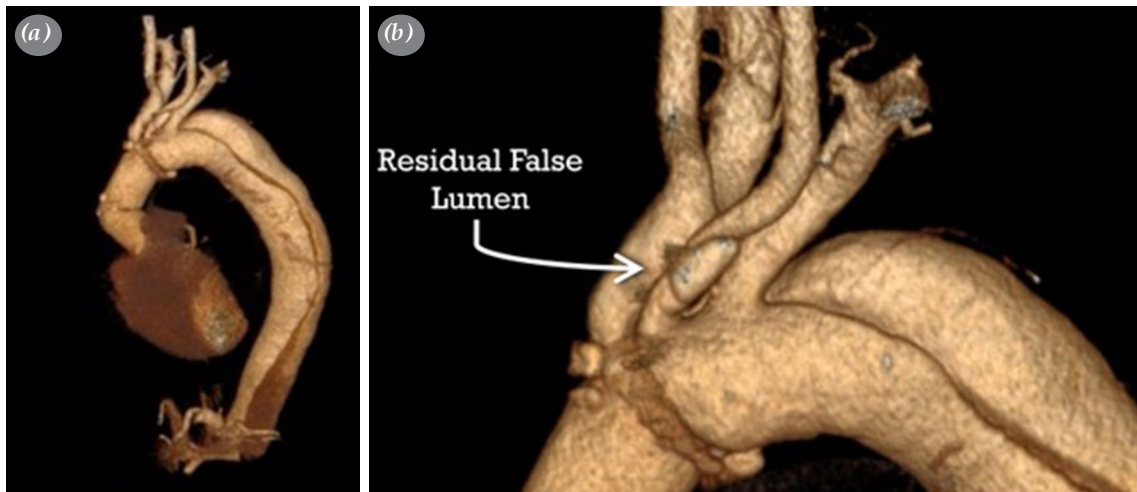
Preoperative computed tomographic images of the patient. (a) Three dimensional rendered images of the dissected aortic arch, and (b) three-dimensional sequence demonstrating a residual patent false lumen in the aortic arch with branch vessels.
